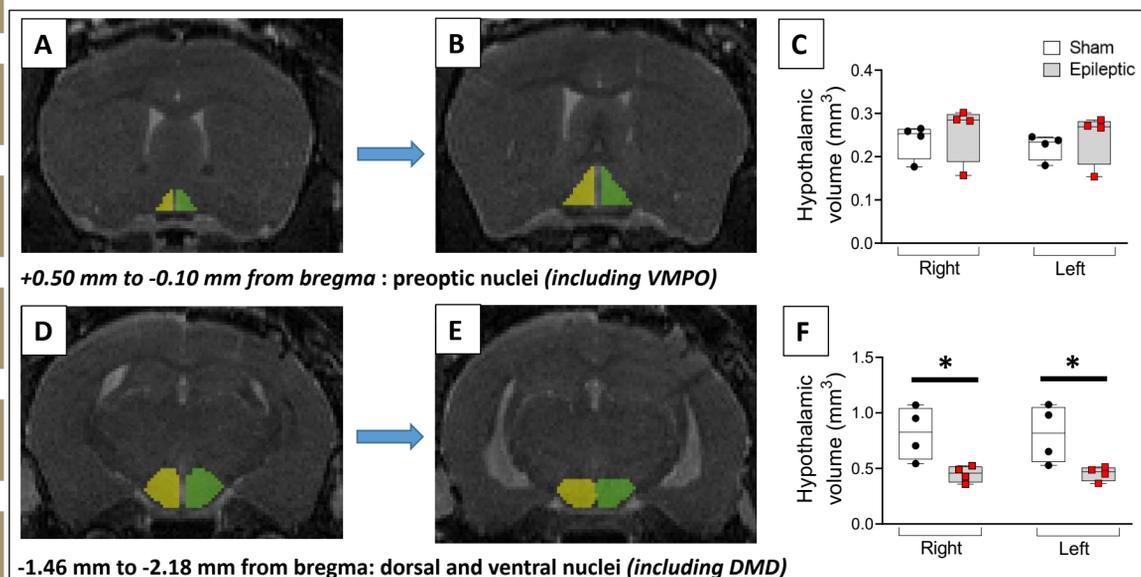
Quantification of hypothalamic volume by 7T MRI.
